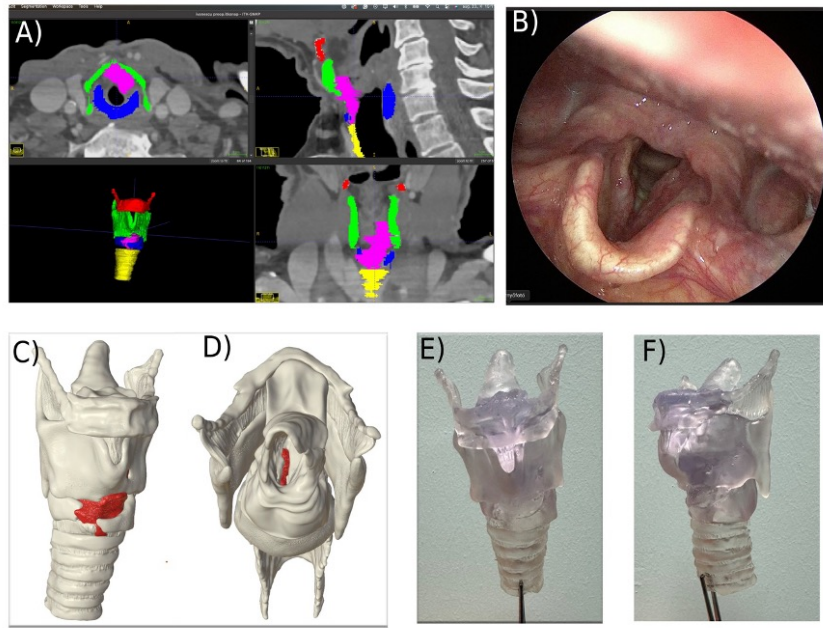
The creation of the preoperative laryngotracheal 3D model is shown in Case 3. A – The manual segmentation is shown with the corresponding CT images. Color legend: red – hyoid bone; green – thyroid cartilage; violet – tumor; blue – cricoid cartilage; yellow – trachea. B – Preoperative endoscopic image of patient#3. C, D – 3D virtual model after post-processing shown from frontal and superior views. E, F – VPP printed model based of *Case 3*, shown from frontal and lateral views.
